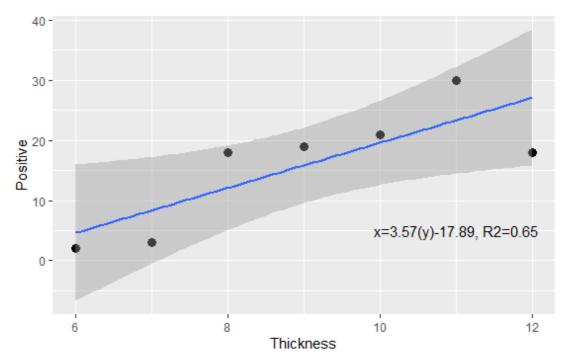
Linear regression between endometrial thickness and positive pregnancy test LBR per cycle occurred only with group 2 and was higher with endometrial thickness 11-12mm (24.1%), one patient had tubal ectopic pregnancy which was treated by methotrexate endometrial thickness at HCG Day was 9 mm. another patient also gets pregnant but early pregnancy ultrasound showed multiple fetal anomalies and the pregnancy was terminated. No significant association between endometrial thickness and miscarriage.
